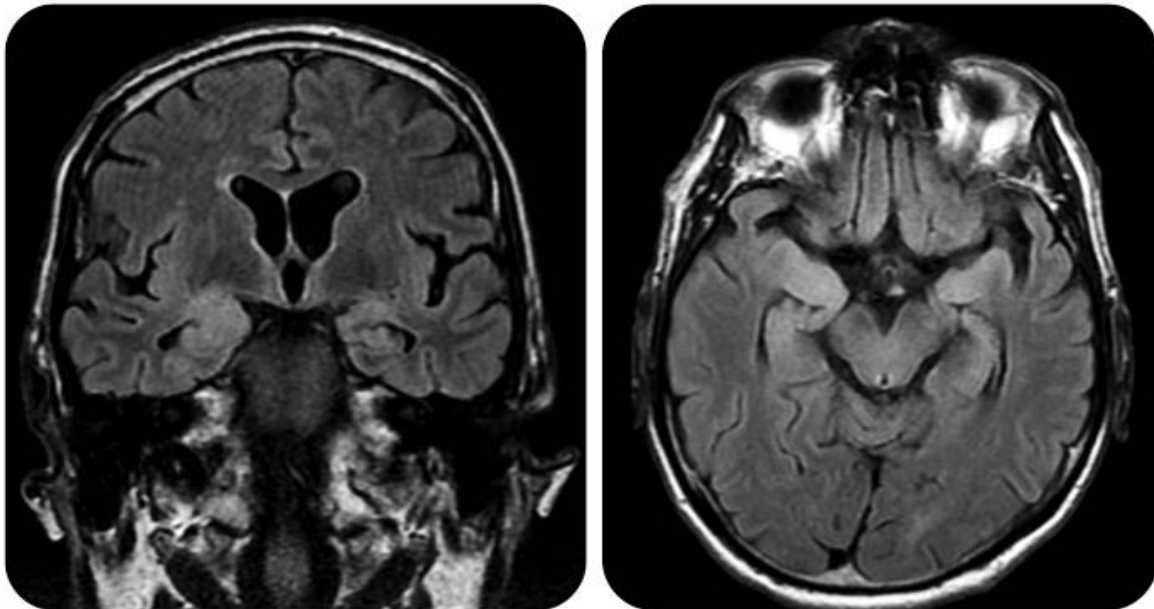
Brain magnetic resonance imaging of patient 7.
